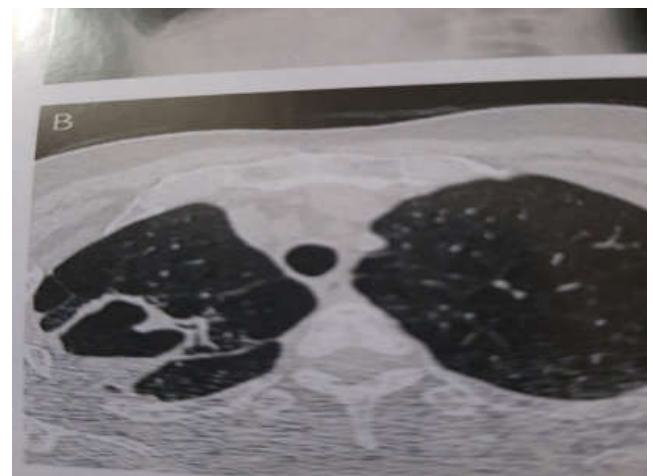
Chest CT scan of the same.
